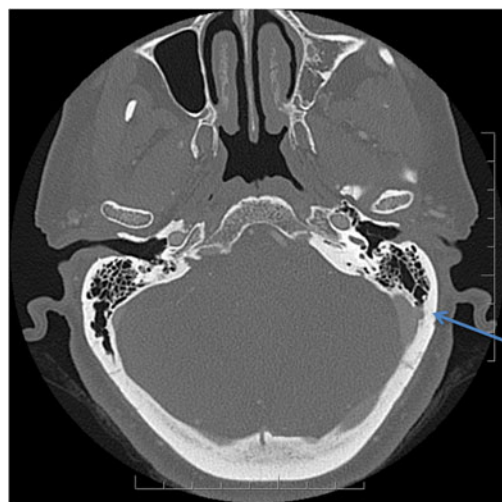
Axial temporal bone computed tomography scan demonstrates a 6 × 4 mm venous out-pouching, projecting from transverse-sigmoid junction through the defect, into the left posterior mastoid air cells (arrow).
